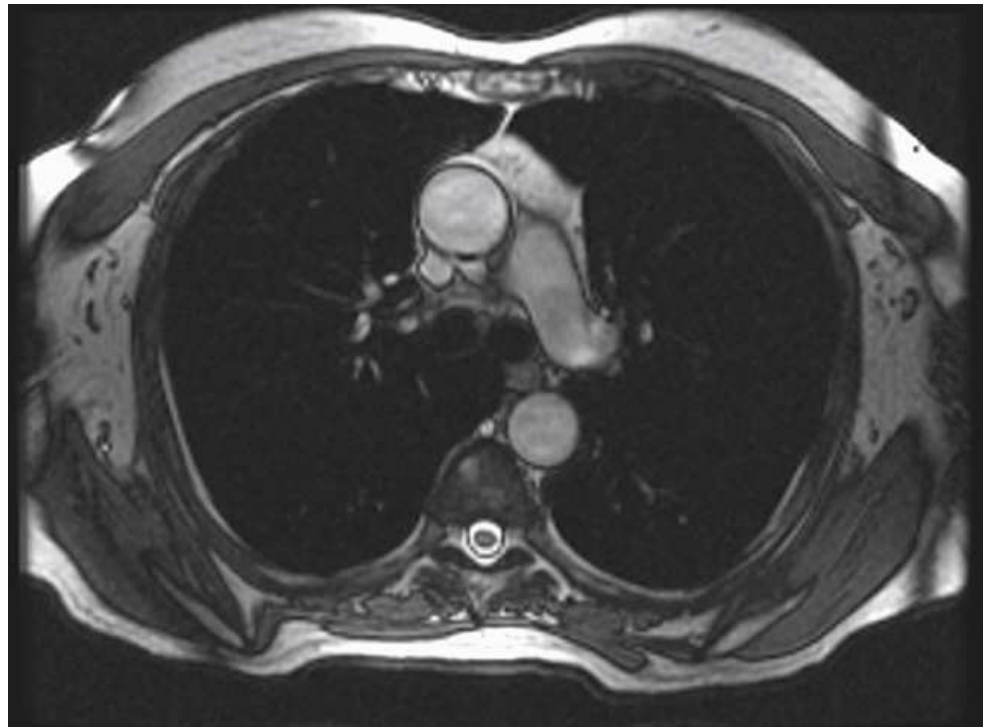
MRI corresponding to level *E* in Fig. 24.30.
